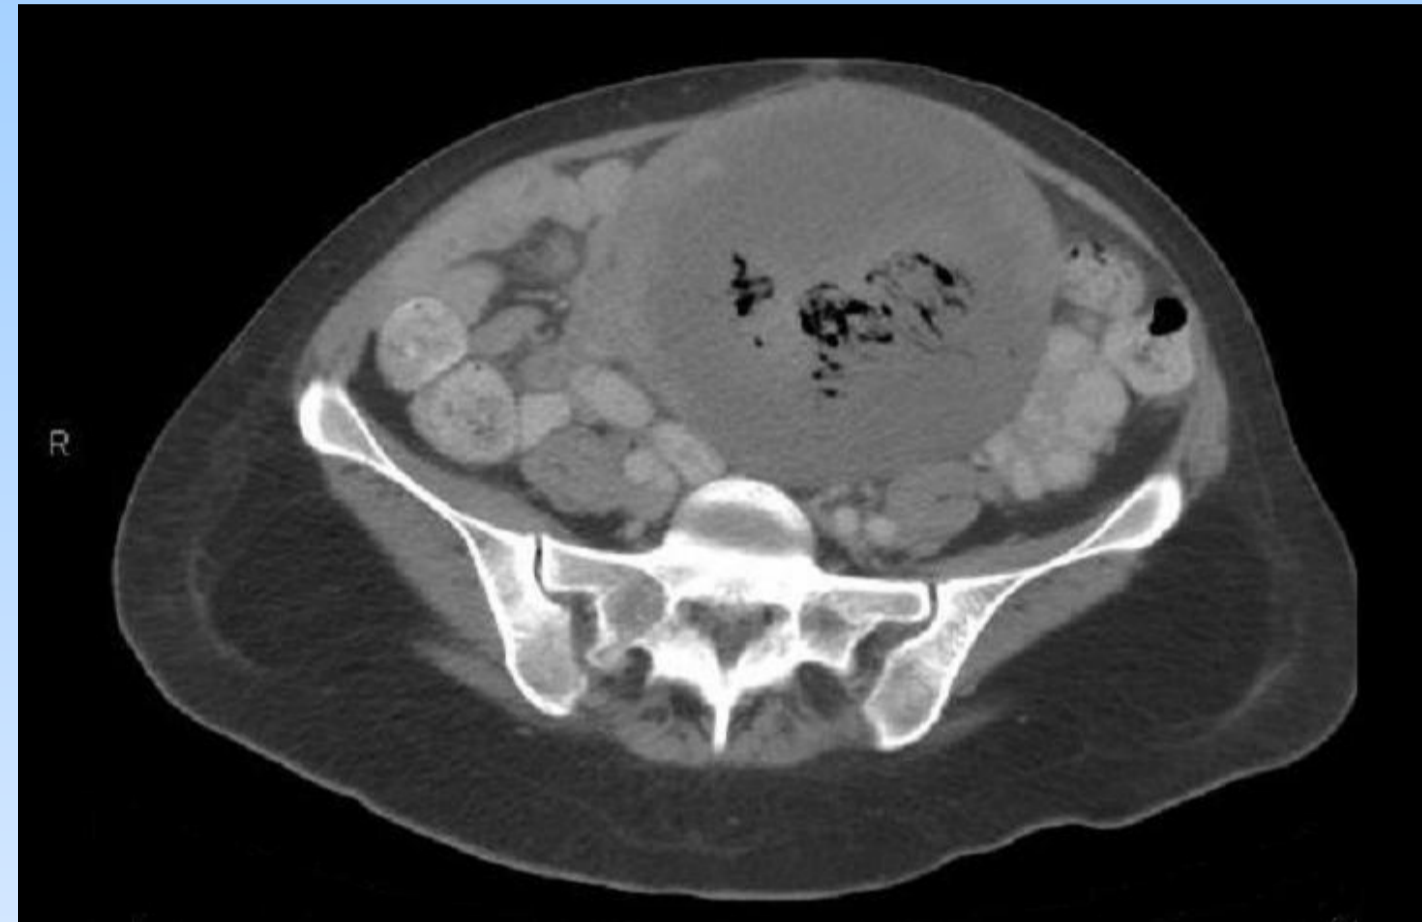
CT scan showing air infiltrating myometrium following postpartum embolization
